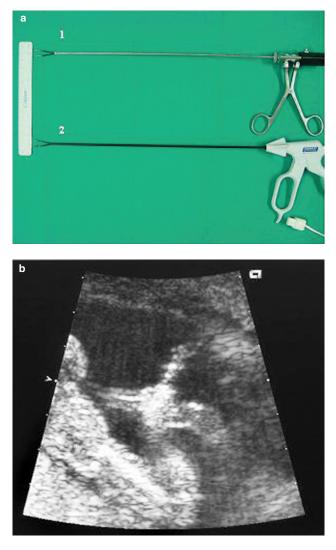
(a) Bipolar forceps: 1, reusable 2.4-mm bipolar forceps (Storz Company); 2, disposable 3-mm Everest bipolar forceps (Gyrus Medical Company). (b) Ultrasound image of bipolar cord coagulation. Image courtesy of Drs Liesbeth Lewi and Jan Deprest, Leuven, Belgium
